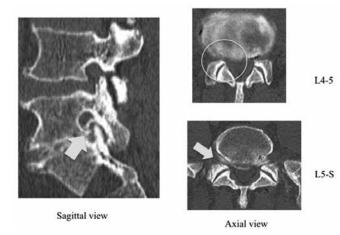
Computed tomography (CT) scans with discography at L5-S before surgery. Arrows indicate right foraminal stenosis at the level of L5-S. Circle indicates right lateral recess stenosis at L4-5.
